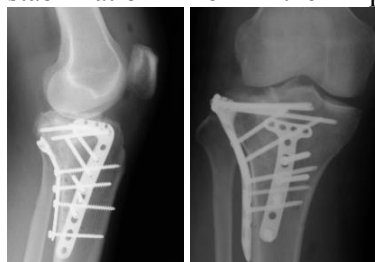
Post operative plain radiograph
